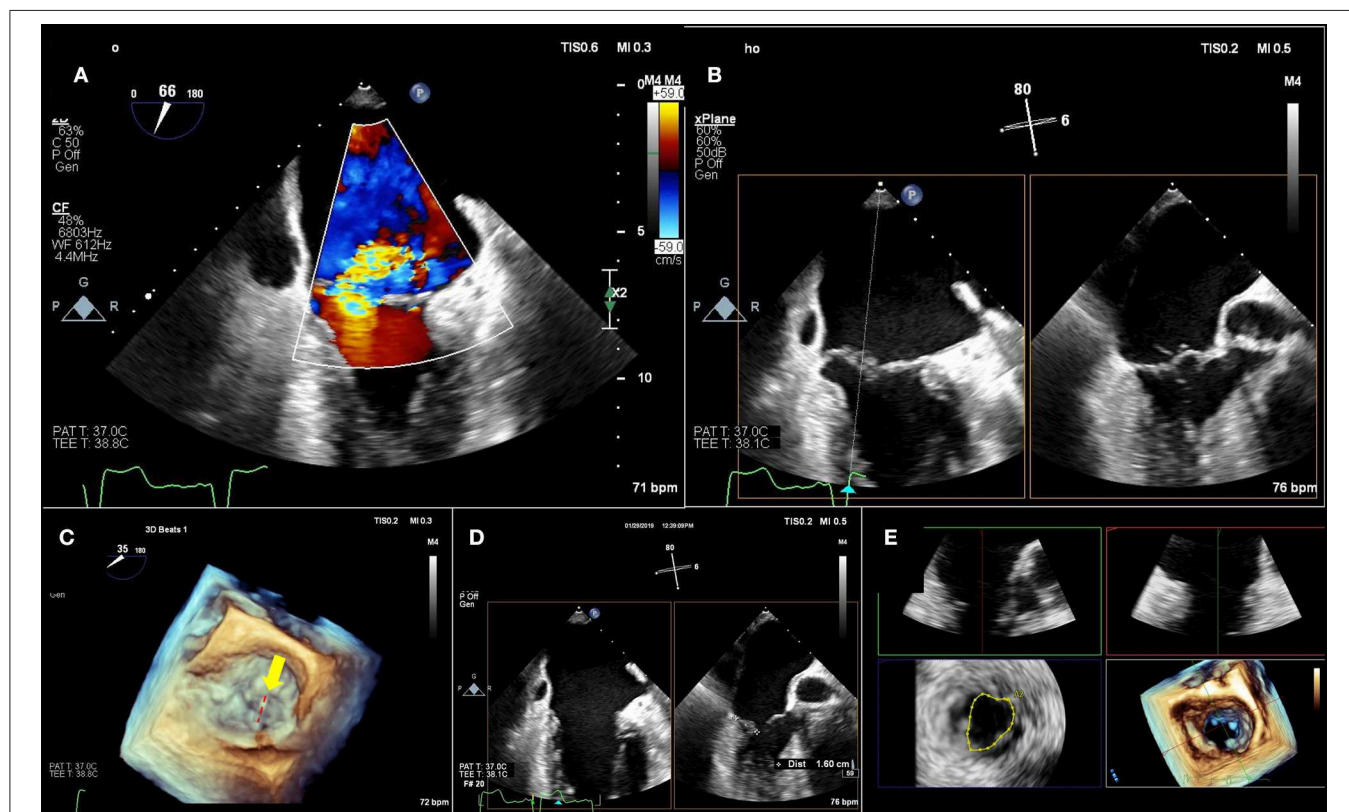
Pre-Mitraclip mitral valve anatomy characterization. (A) A large, medial regurgitant jet is demonstrated. (B) On bi-plane imaging of the region, medial anterior flail segment is demonstrated. (C) A 3-dimensional echocardiographic surgical view demonstrates A2-A3 scallop flail (yellow arrow) with a ruptured chord (red-dashed line). (D) Leaflet length in planned “grasping view” is measured and appears adequate for insertion into edge-to-edge repair device. (E) 3-Dimensional echocardiographic reconstruction demonstrates adequate baseline mitral valve area of 4.4 cm^2 , greater than the 4.0 cm^2 cutoff.
